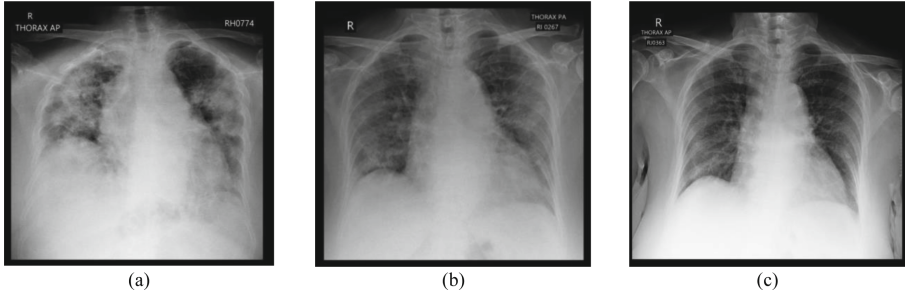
Case 1. (a) first thorax radiograph. (b) after 14 days of secretome last injection. (c). 1 month after the last secretome injection.
